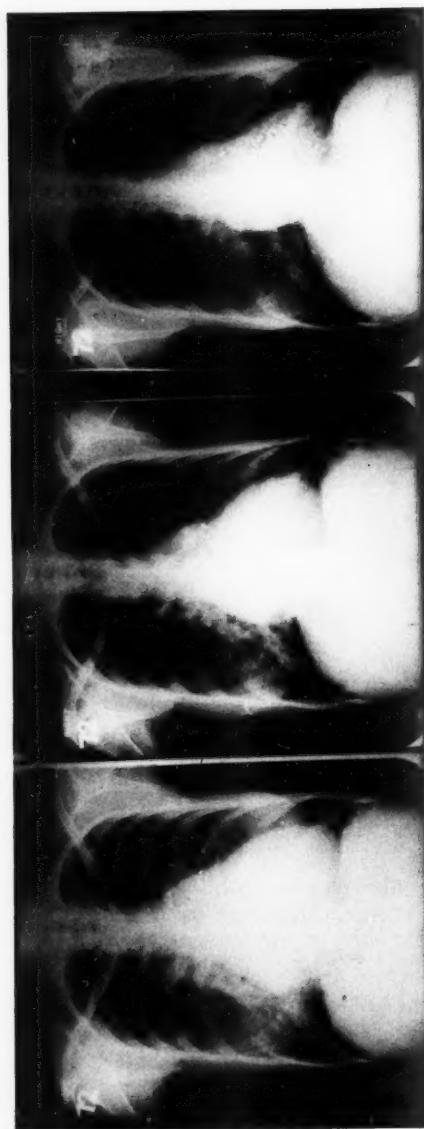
X-rays of the first surviving patient showing progressive decrease in the heart size following closure of an atrial septal defect.
